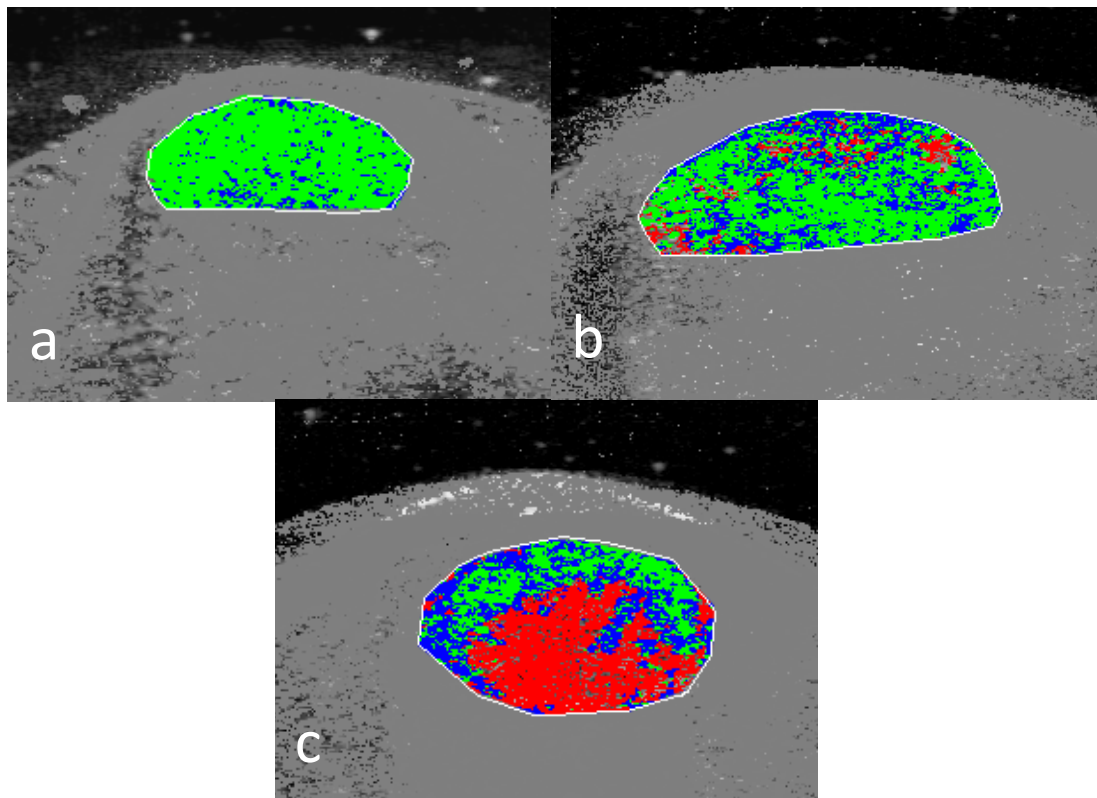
Ultrasound tissue characterisation of the Achilles tendon midsubstance. (a) Normal Achilles tendon characterised by a high proportion of echo-type I (green pixels) representing aligned tendon bundles. (b) Reactive tendon pathology due to tendon thickening and the presence of diffuse speckling of echo-type II (blue pixels) and echo-type III (red pixels). (c) Degenerative tendon pathology indicated by significant focal area of echo-type III (red pixels).
